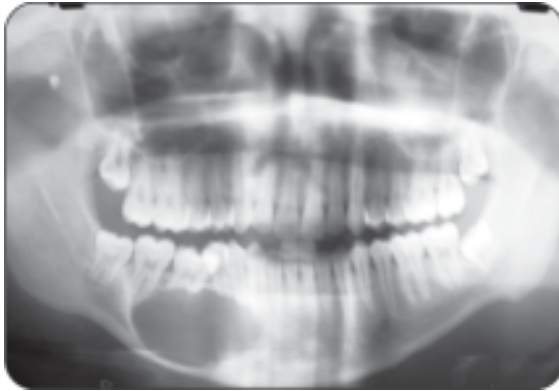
Radiograph of central giant cell granuloma
